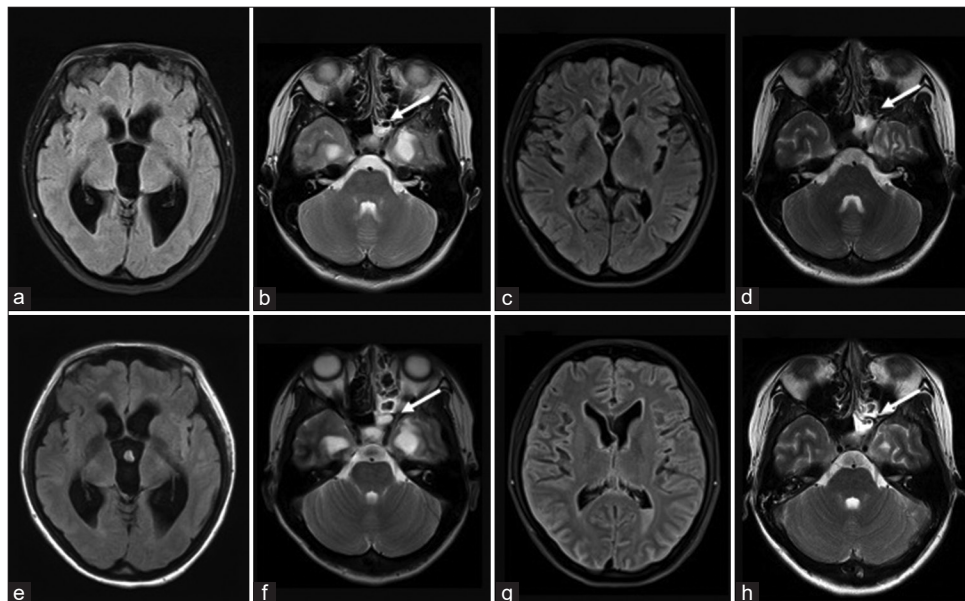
(a and b) First visit day, (c and d) 14 months later, (e and f) 19 months later, (g and h) 22 months later (admission day). (a, c, e, g) Axial FLAIR MRI showed change of the size of ventricles. (b, d, f, h) Axial T2-weighted MRI showed CSF accumulation (white arrow).
